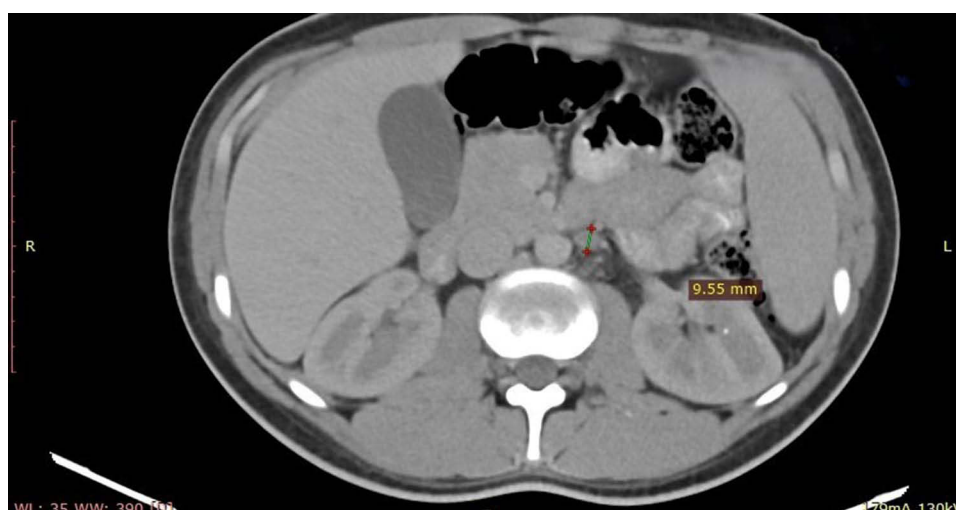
Axial contrast-enhanced CT of the abdomen revealing further para-aortic lymphadenopathy; index node short axis 9.6 mm, within a cluster of pathologic-appearing nodes. (R: Right, P: posterior).
